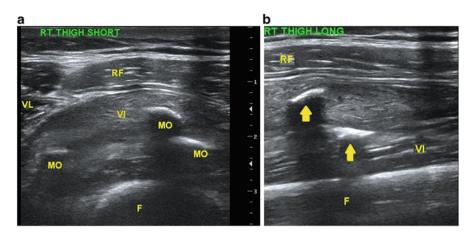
A musculoskeletal ultrasound short axis (a) and long axis (b) views demonstrating heterotopic ossification within the vastus intermedius (VI) consistent with myositis ossificans (MO). RT right, RF rectus femoris, VL vastus lateralis, F femur. Arrows demonstrate myositis ossificans
